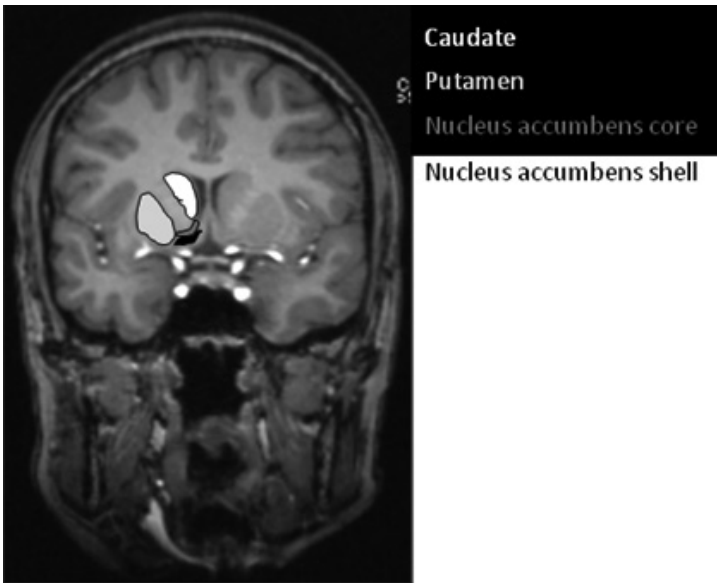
Coronal view of the striatum (caudate and putamen) and the nucleus accumbens (core and shell) from a T2-weighted MRI scan
